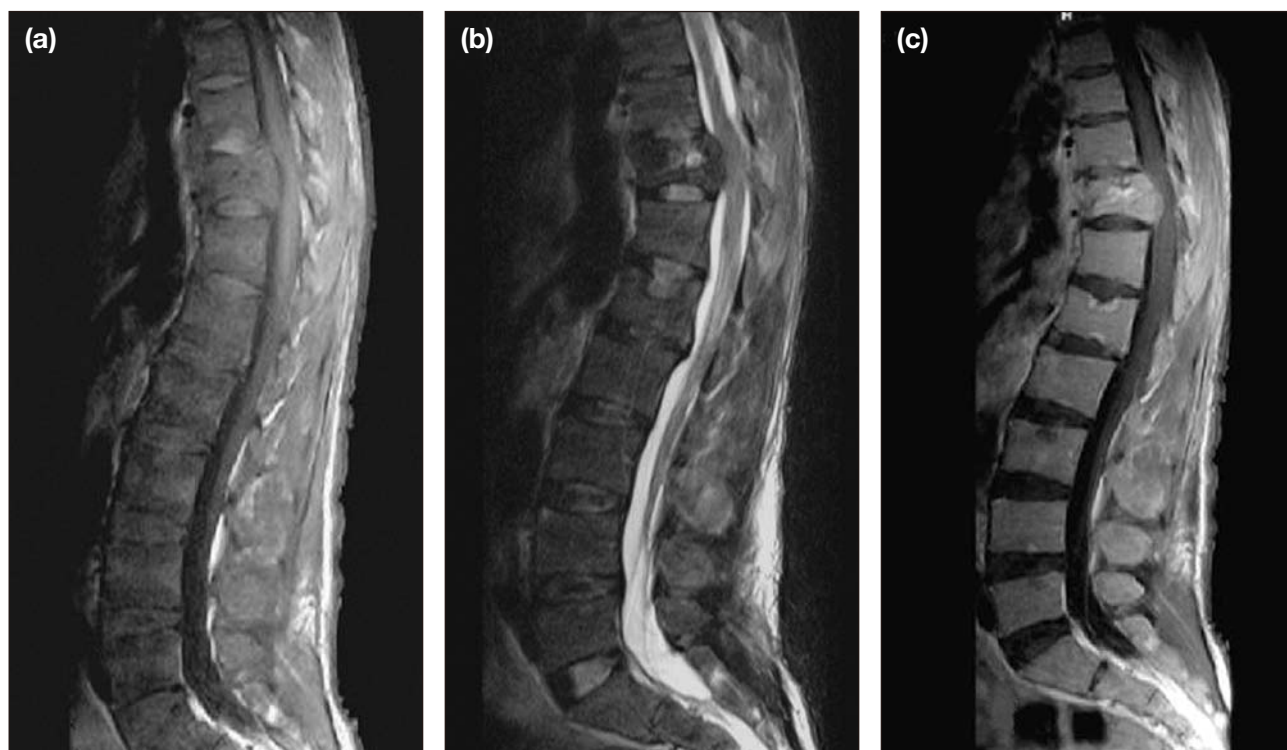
Sagittal (a) T1-weighted and (b) T2-weighted magnetic resonance images demonstrating a low-signal intensity mass invading the T11 vertebra and compressing the spinal cord; and (c) post-gadolinium injection image showing enhancement of the lesion.
